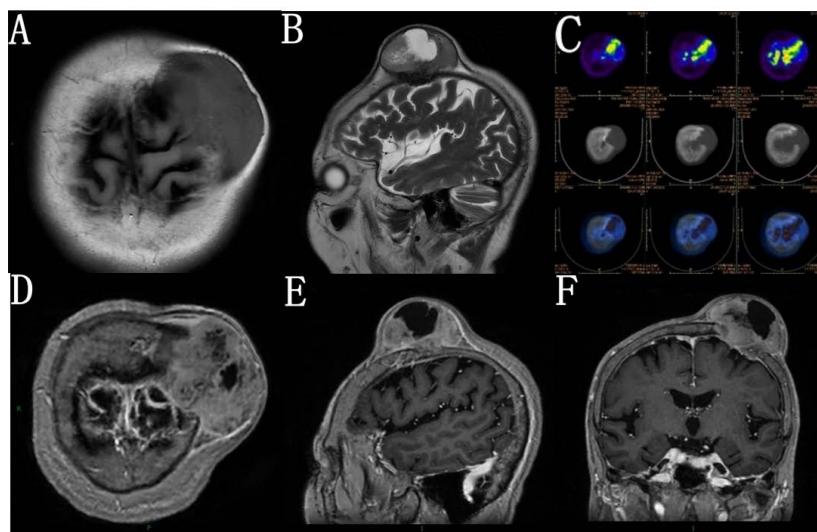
Cranial MR+ PET-CT TIWI (A) showed low signal, T2WI (B) showed uneven slightly high signal, within which cystic lesions were seen, local breakthrough of the frontal bone, obvious bone destruction was seen, the lesion was poorly demarcated from the dura mater, and the lesion was unevenly and obviously strengthened on enhancement scans (D E F); PET-CT (C): osteolytic bone destruction was seen in the left frontal-parietal bone, and the shadow of a round-like soft-tissue mass was seen in the local area, and multiple calcified foci were seen at the edges, FDG uptake, SUVmax11.3.
